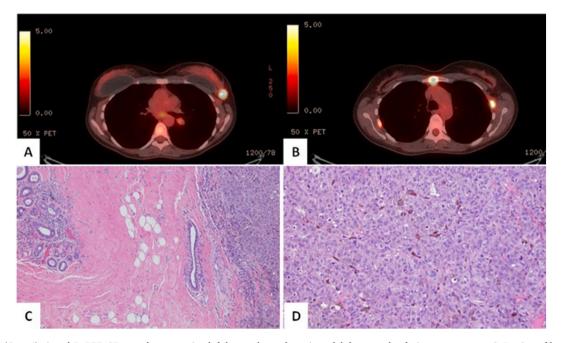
(Case 4): A and B. PET/CT scan demonstrating left breast, lung, thoracic nodal, bone, and soft tissue metastases. C. Portion of breast parenchyma (left) with fibrous stroma. A well-circumscribed nodule of melanoma is present on the right. (100 X) D. Higher power shows the tumor to be composed of epithelioid cells with amphophilic cytoplasm and enlarged ovoid nuclei with prominent nucleoli (400 X).
